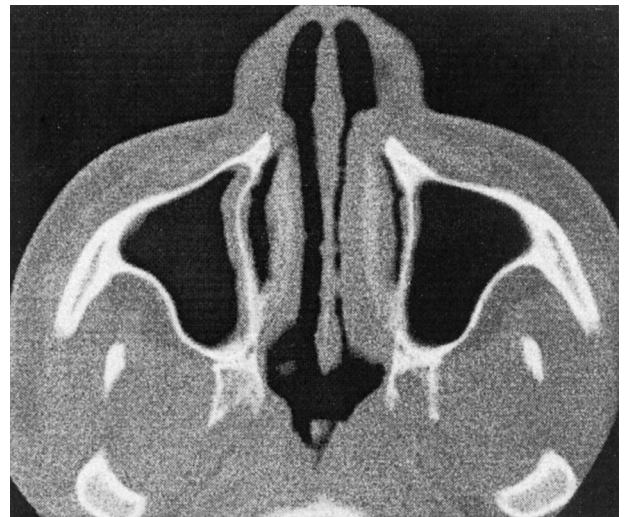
Nasal sarcoidosis, axial computed tomography scan. Sarcoid granulomas on the nasal septum and inferior turbinates.
